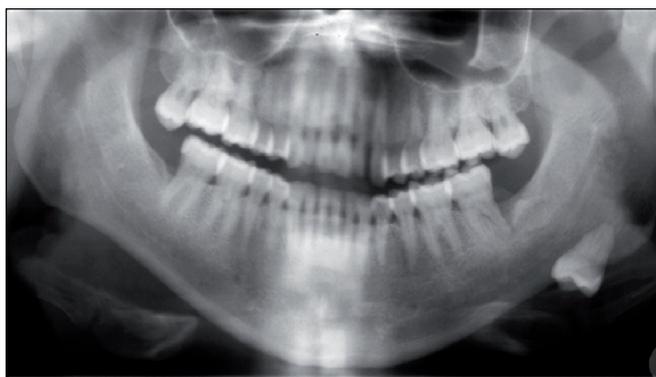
Panoramic radiography taken before removal of the left third mandibular molar confirming the diagnosis of tooth displacement.
